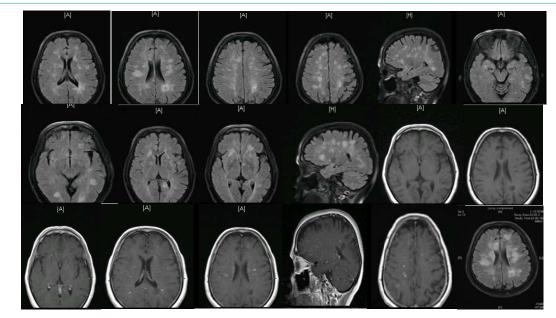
T2WI and FLAIR sequence shows multiple rounded lesions involving basal ganglia. Axial contrast enhanced T1 WI shows that hyper intensities demonstrate punctate and ring enhancement.
